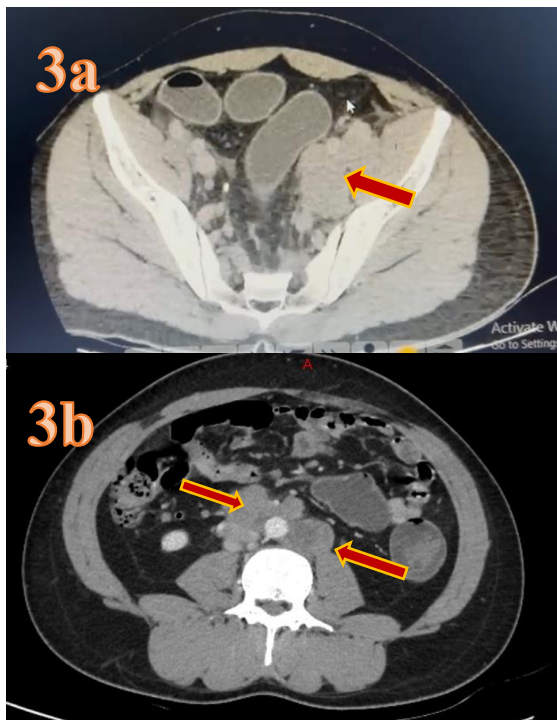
CT pelvis images - the enlarged lymph nodes along the iliac vessels, 3b the enlarged left infra renal para-aortic and precaval lymph nodes.
